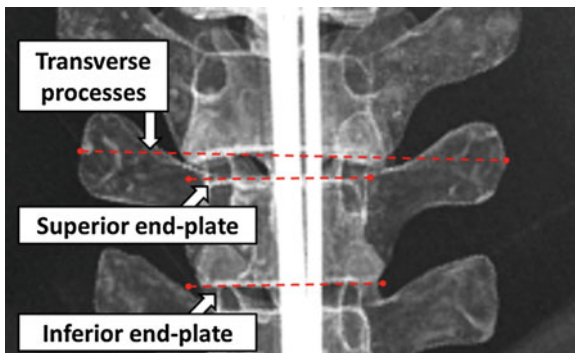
Anatomical features for spinal curvature measurement. Superior and inferior end-plates are conventionally used in radiographic measurements. The transverse processes are also visible in ultrasound
